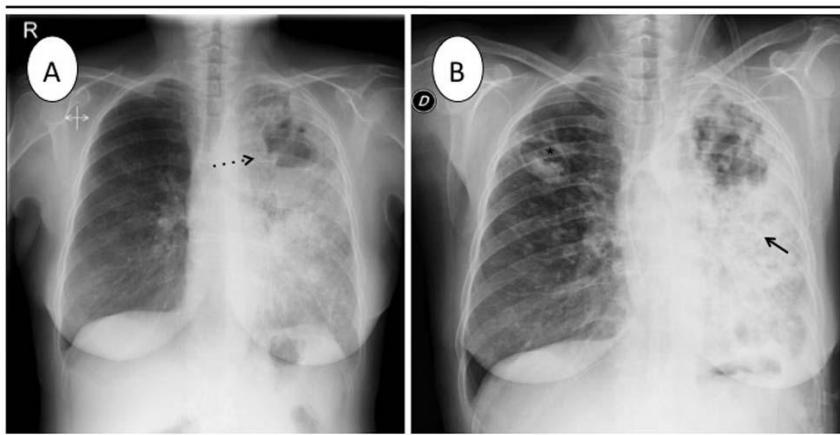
62 year old women treated with chemotherapy for cervical carcinoma who was admitted with cough and expectoration. The CXR showed a cavitated image in the anterior/apical segment of the upper left lobe (dashed arrow) and alveolar infiltrate in the upper right lobe that cavitated during its evolution (asterisk and arrow). Sputum culture showed *Serratia marcensens*, and the radiographic pattern was cavitary pneumonia with fungal invasion (aspergilloma) in the lesion of the upper right lobe.
